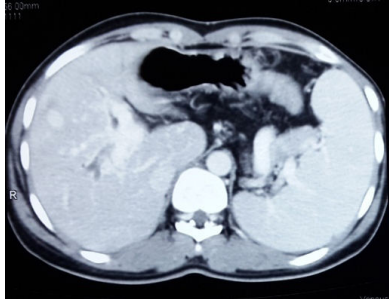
CT abdomen axial section showing liver.
